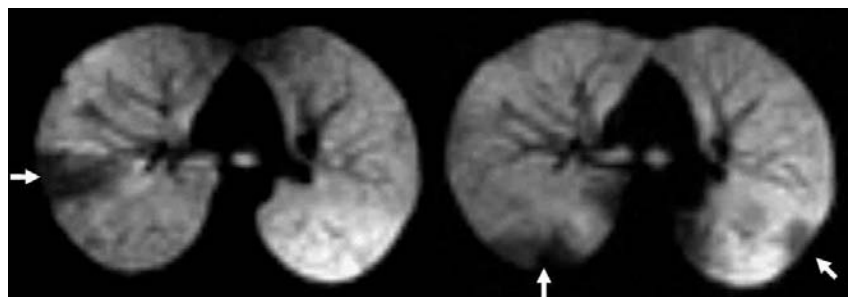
Axial H^3He MR images obtained 12 days apart demonstrate resolution of a right lower lobe ventilation defect and development of new ventilation defects.
